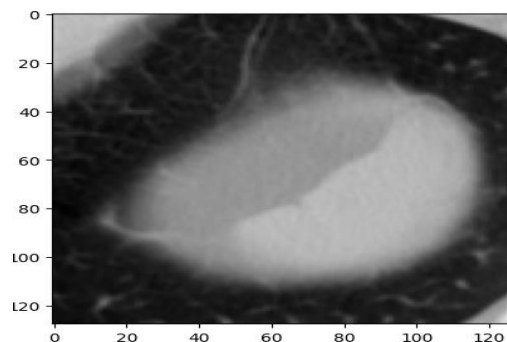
A CT scan slice of a sample 3D patch nodule
